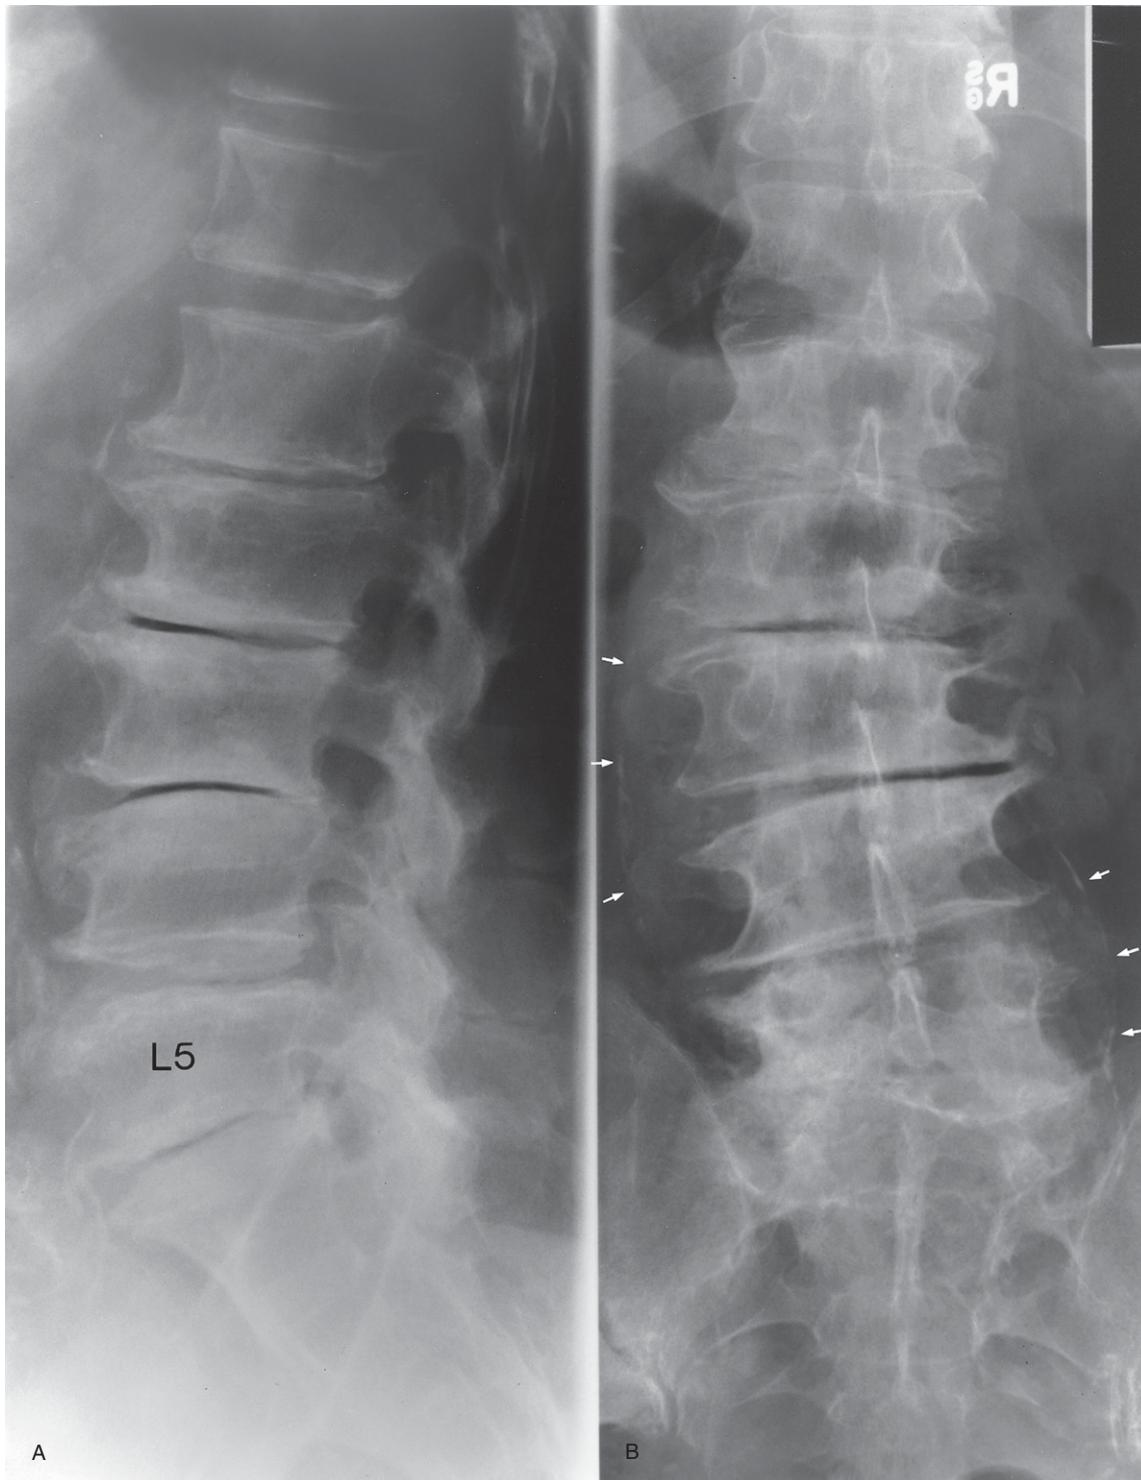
(A and B) Lumbosacral spine lateral and anteroposterior plain X-ray images showing the advanced discogenic spondylosis with partial calcification in the abdominal aorta aneurysm (small arrows). L5 = fifth lumbar vertebra.
